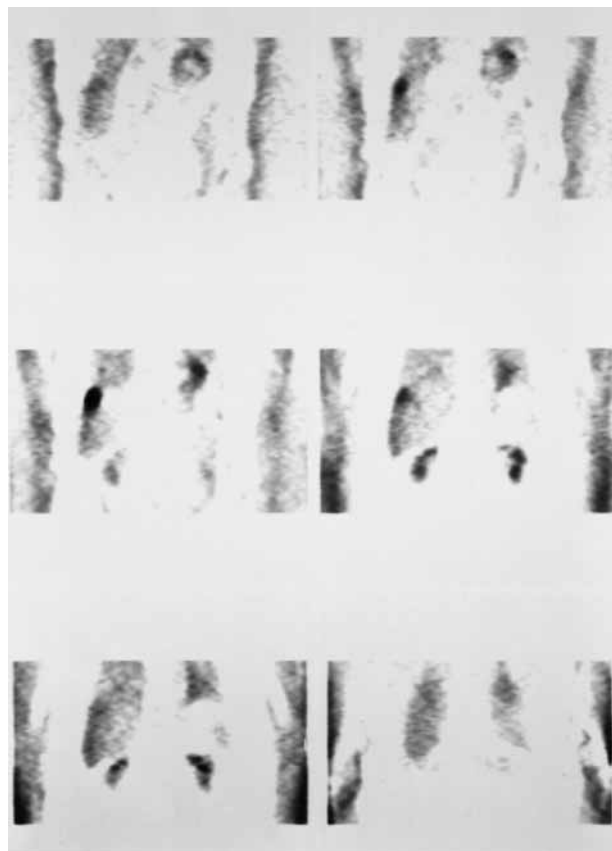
18F-FDG PET study of a patient (V.J.) with liver metastasis spread from colonic adenocarcinoma demonstrating a significantly increased FDG uptake (SUV_{LBM} :9.8).
